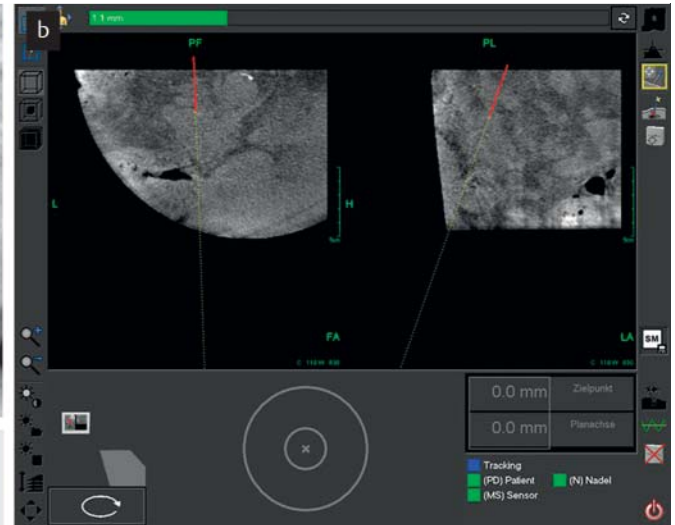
FD-CT-/EMN-gesteuerte Biopsie einer Massenläsion im Pankreas-kopf. a Die präinterventionelle axiale MSCT-Aufnahme eines 74 Jahre alten Mannes in Bauchlage zeigt die Massenläsion innerhalb des Pankreas-kopfes. b Die FD-CT-/EMN-Bilder in axialer und sagittaler Projektion zeigen die virtuelle Nadel mit ihrer Spitze innerhalb der Massenläsion, bezüglich der die Diagnose eines Adenokarzinoms gestellt wurde.
